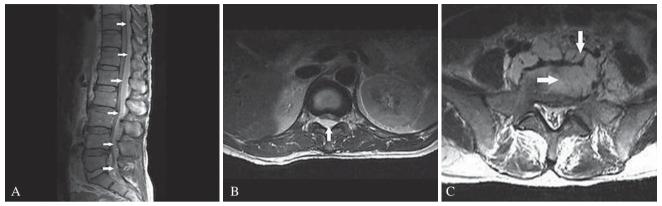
(A) Sagittal view of T1-weighted MRI of thoracic-lumbar spine revealed a high-intensity lesion (arrows) extending from T9 to S1 dorsal epidural space. (B) Axial view of T1-weighted MRI of thoracic-lumbar spine revealed the enhanced mass (arrow) located in the right posterior aspect of spinal canal compressing the spinal cord. (C) Axial view of T1-weighted MRI of L5-S1 disc space revealed the hyper-intense lesion (arrows) located in disc space and prevertebral space.
